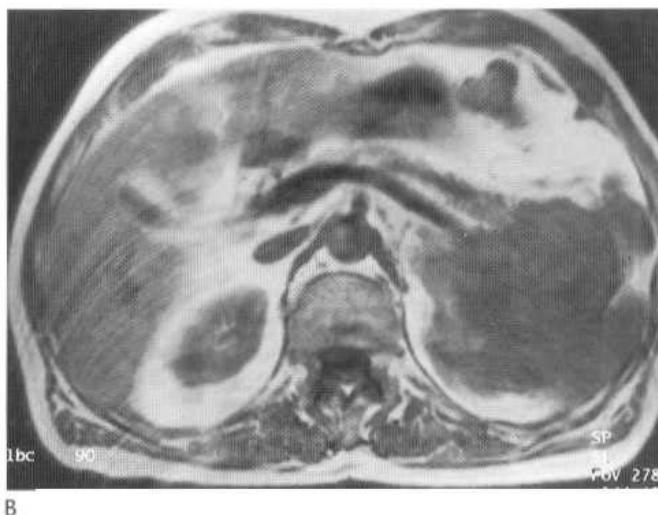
Renal metastasis on STIR sequence (A) and T-weighted MRI (B). Features of the mass are essentially identical to a primary renal cell carcinoma.
